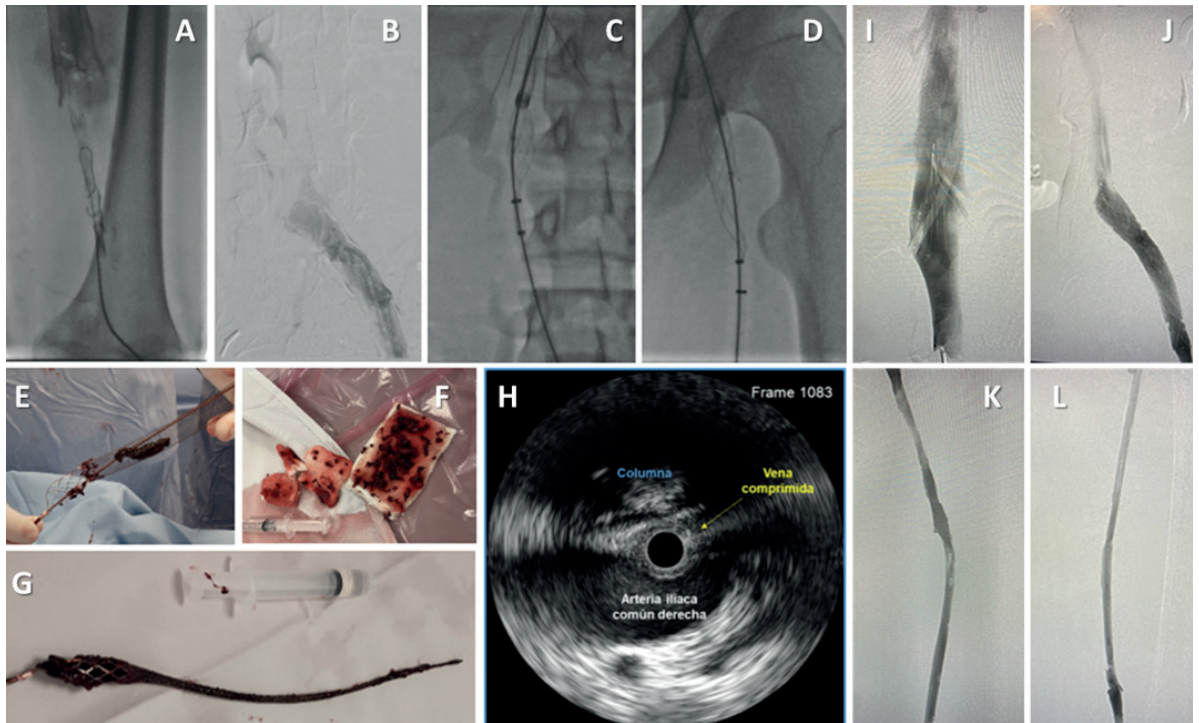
A) Access to the thrombosed popliteal vein. B) Extensive iliofemoral thrombosis and a large thrombus in the inferior vena cava. C) ClotTrierer tunneling, with the coring element deployed in the inferior vena cava outside the introducer and the collection bag deployed within the vein to avoid interaction with the IVC filter. D-G) Mechanical thrombectomy with removal of abundant thrombi. H) Intravascular ultrasound at the compression site. I-L) Final outcome.
